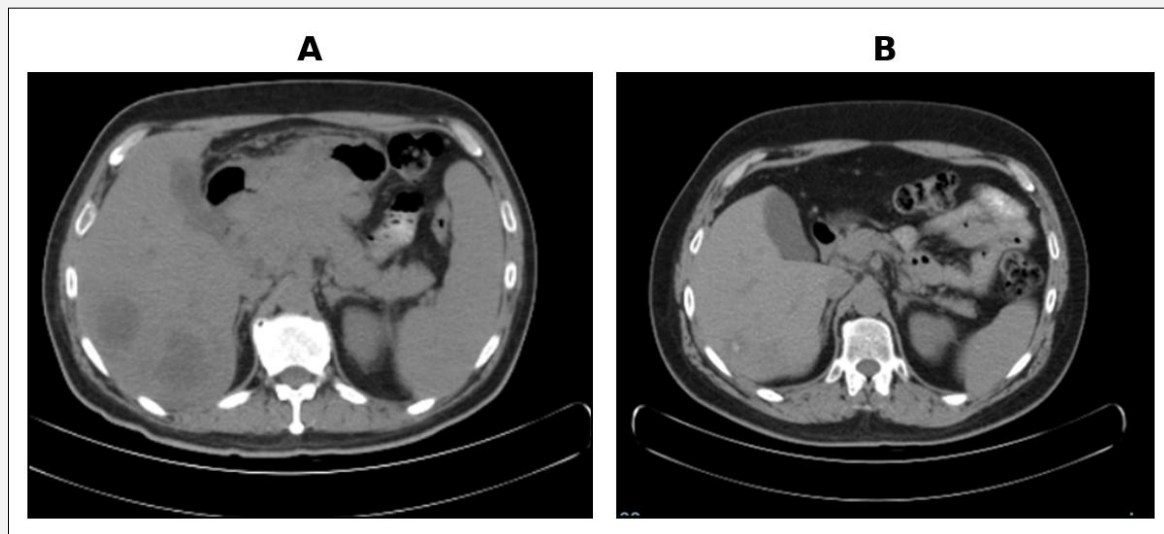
Axial computed tomography images of the liver.
